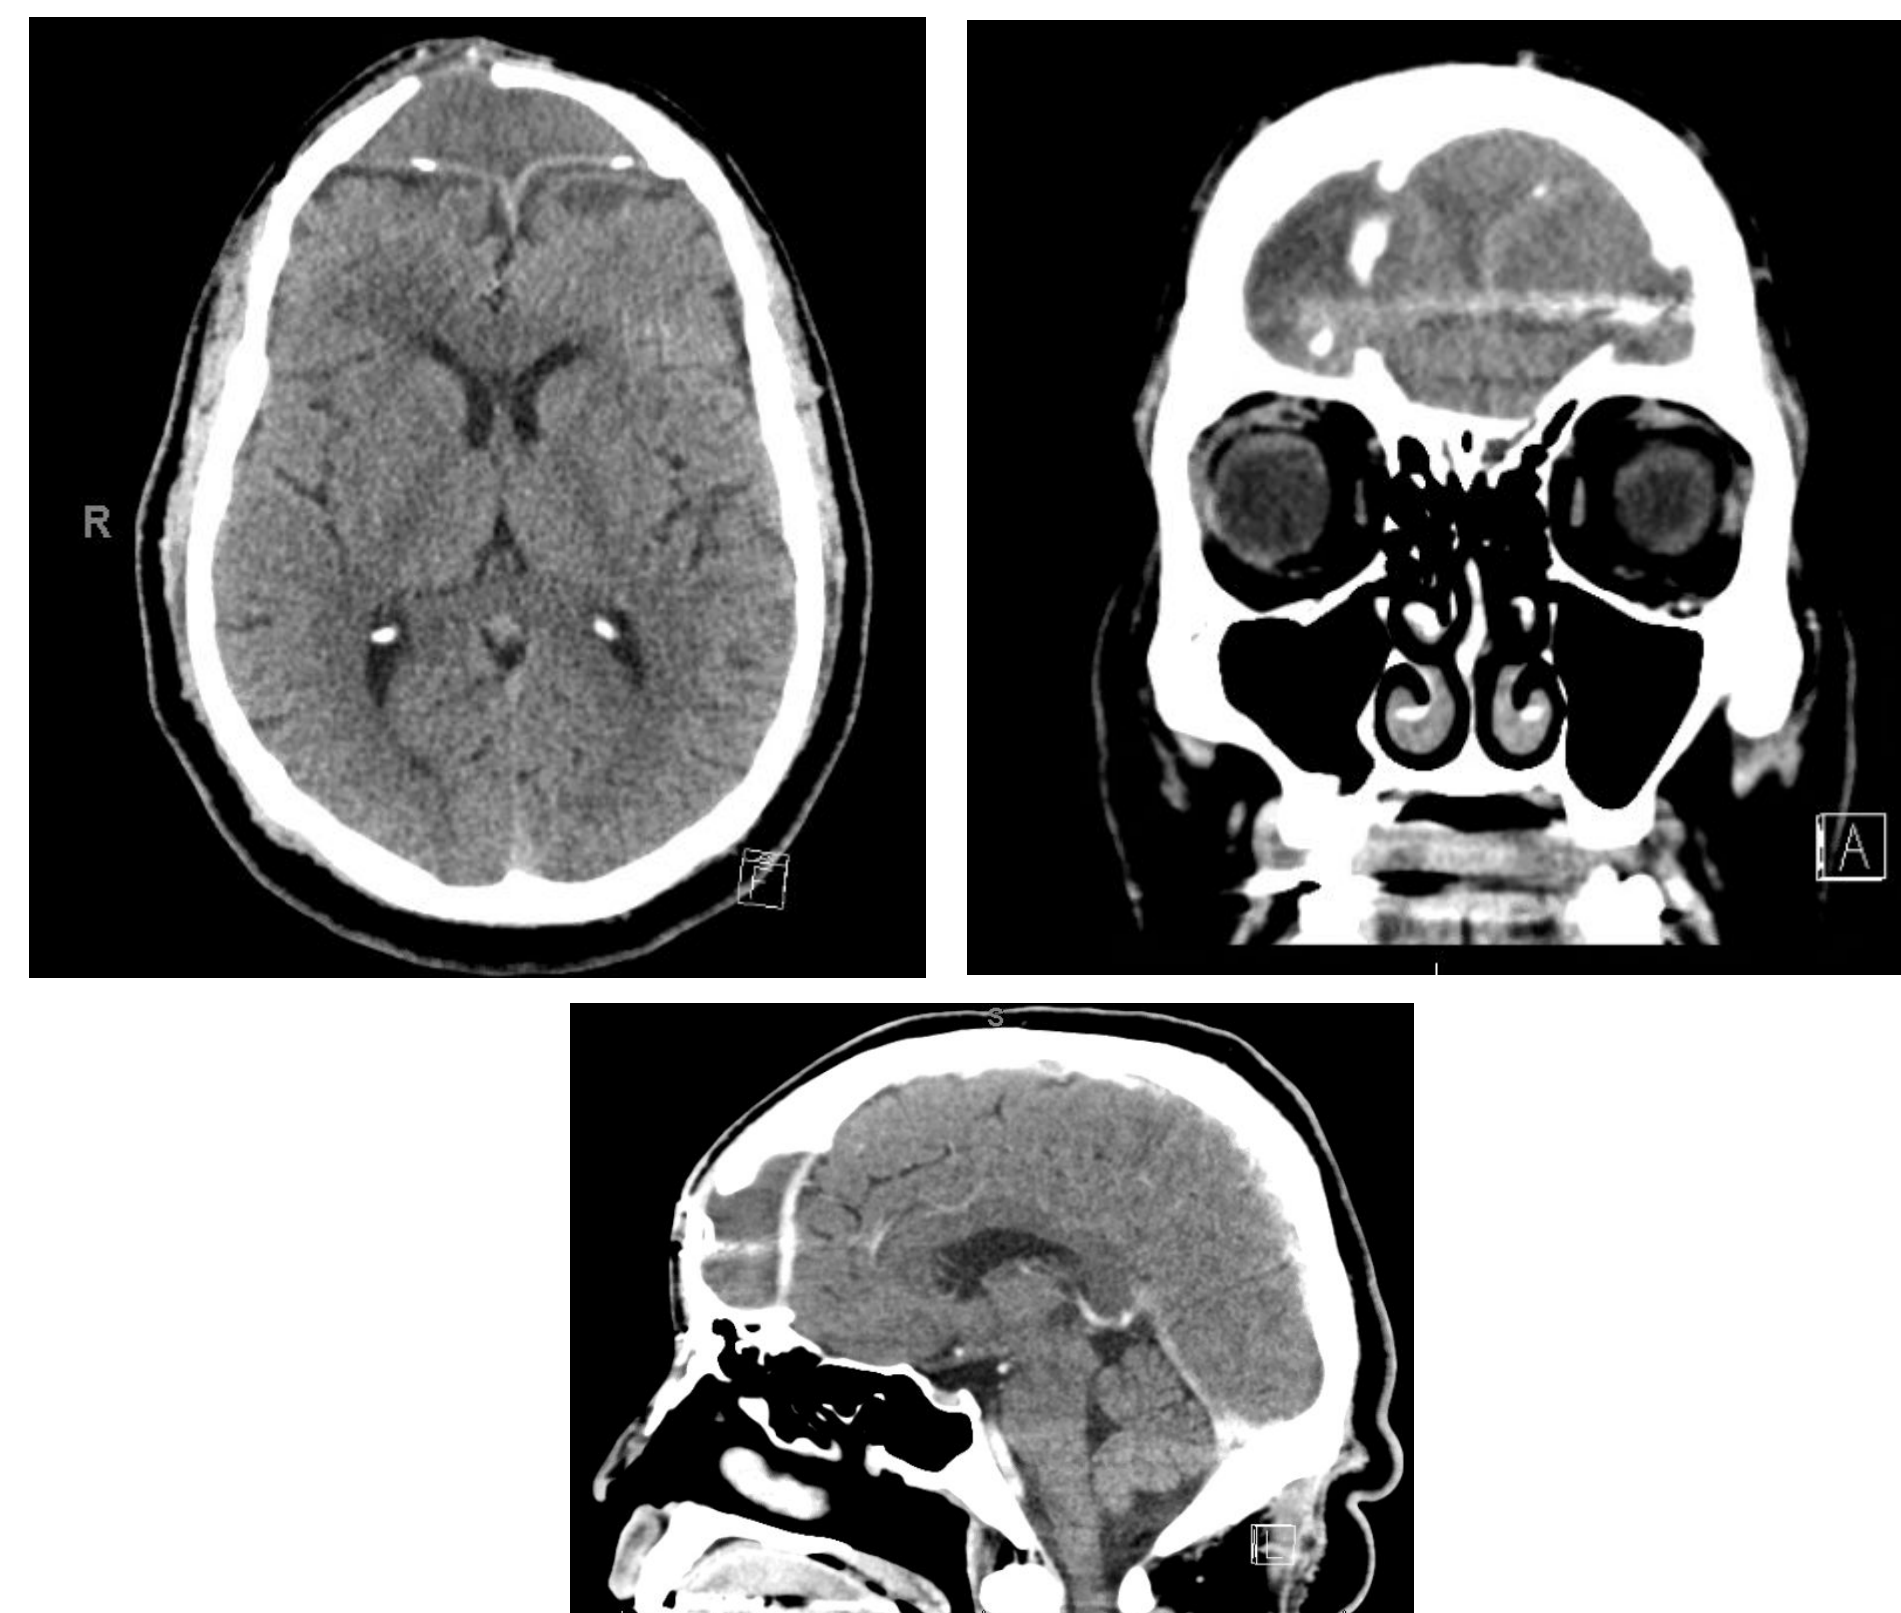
CT head ~1 month after neurosurgery
